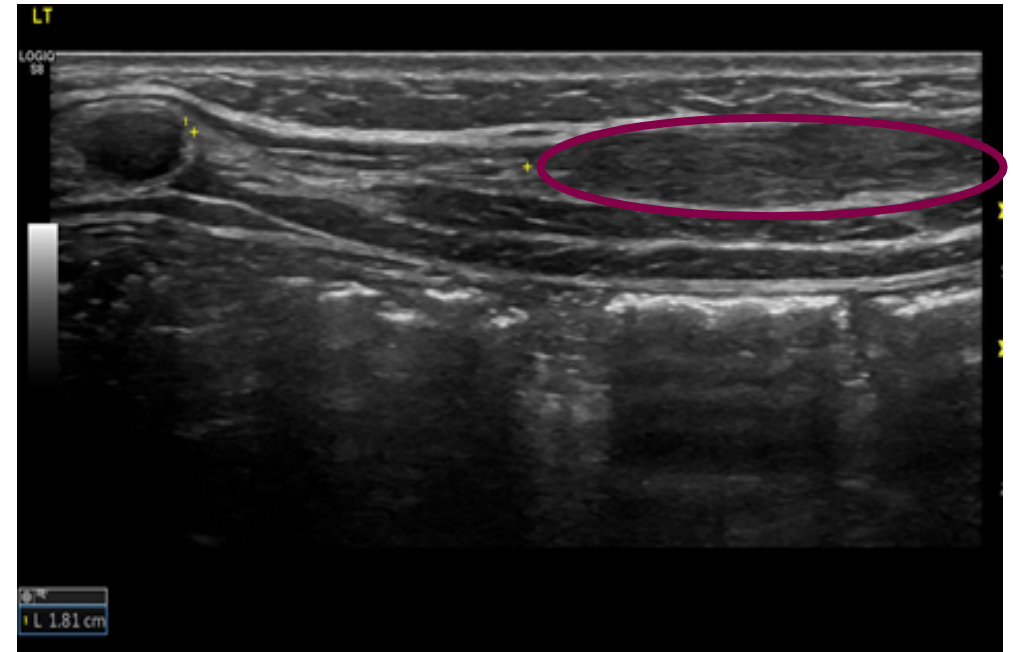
Figure b left chest wall lesion intra-operative ultrasound
